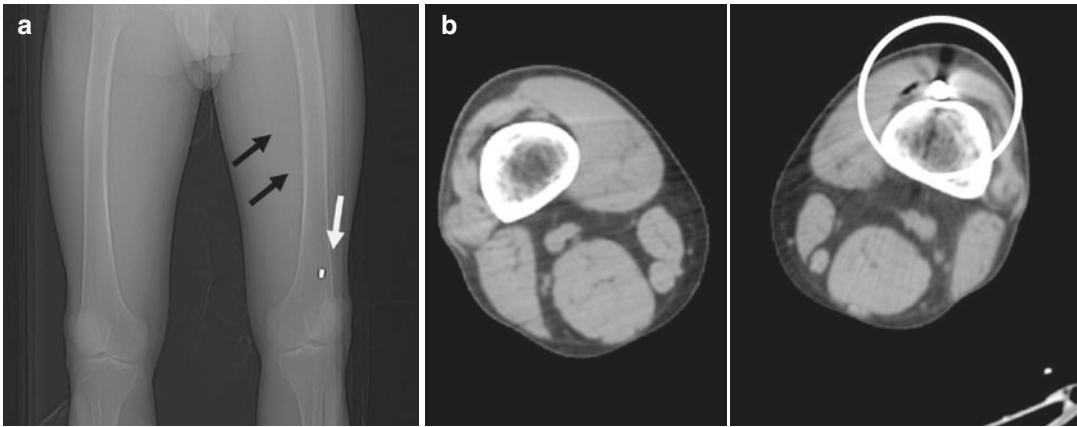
(a) Scout CT view show bullet in the upper left side of the knee; (b) axial view of CT scan shows the bullet to be lodged deeply in the muscle to the left knee
